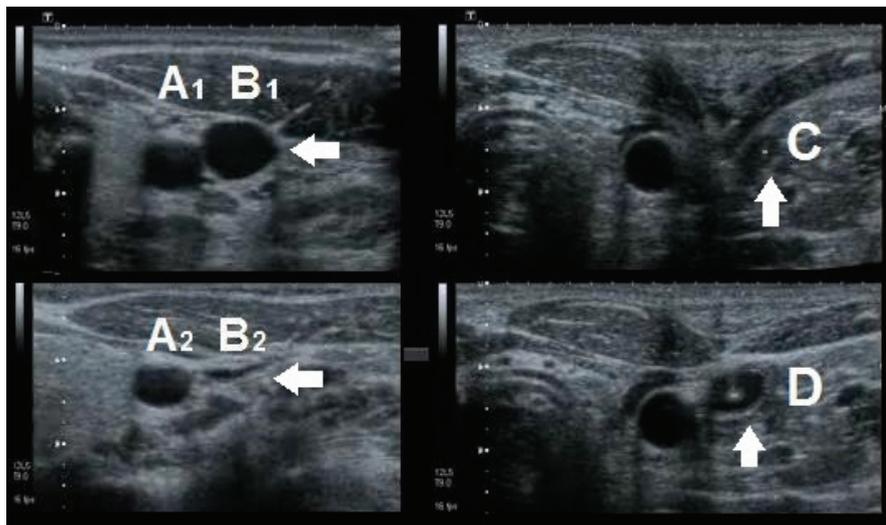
The ultrasonography is a powerful resource to help the vascular puncture in difficult situations. The images above were obtained by ultrasound of the right cervical region and show the anatomical relationship between the carotid artery (A) and internal jugular vein (B) and can be observed that the vein is much more compressible. The images to left side show venous distention with (A1B1) and without (A2B2) use of the Valsalva maneuver, respectively. C - During percutaneous venous puncture the image echogenic represents the correct position of the needle into internal jugular vein (arrow)
